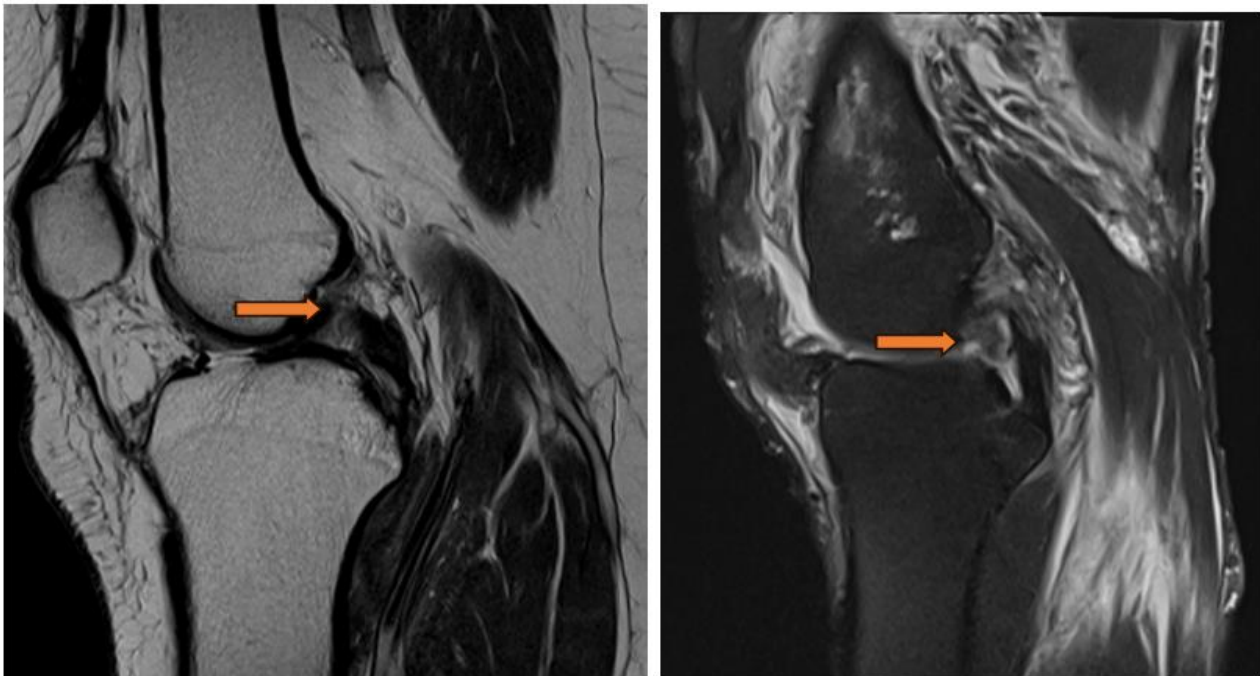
MRI Right knee joint, PD and PDFS sequences, sagittal section shows intrasubstance PDFS hyperintensities along with discontinuity of fibres of anterior cruciate ligament, consistent with Anterior cruciate ligament tear
